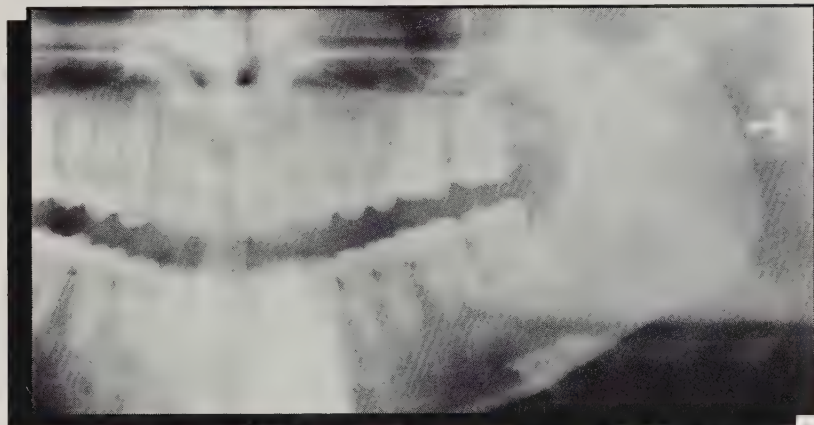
Panoramic radiograph showing gap arthroplasty of left TMJ and two screws to secure silastic implant to glenoid fossa.
